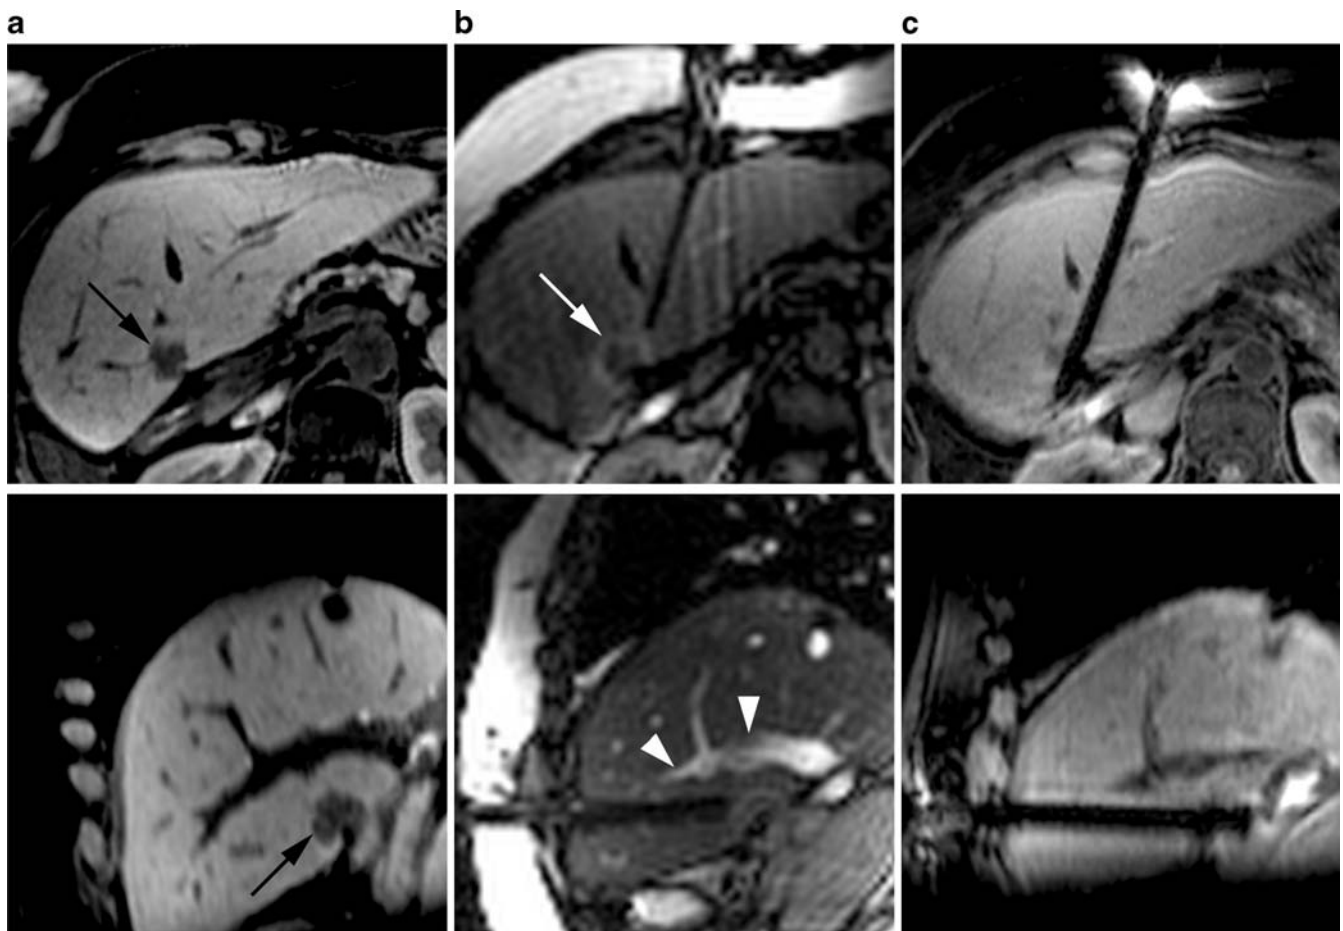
Targeting under MR imaging of a recurrent nodule (lesion 4) in a 54-year-old woman (patient B) after right hepatectomy with four wedge resections for synchronous liver metastases of colorectal origin. a 3D T1-weighted VIBE images (TR, 5.6 ms; TE, 2.7 ms; FA, 10°; matrix, 320×256 ; section thickness, 2 mm) reconstructed in the axial oblique plane (top) and sagittal oblique plane (bottom) are used for planning. A 1.8-cm large, irregular and hypointense nodule (black arrows) at the posterior and inferior aspect of segment 4 and in contact with the site of a previous metastasectomy. b "Fluoroscopic" bSSFP sequence (TR, 4.3 ms; TE, 2.2 ms; FA, 70°; matrix, 128×128 ; section thickness 5 mm) shows the RF electrode
